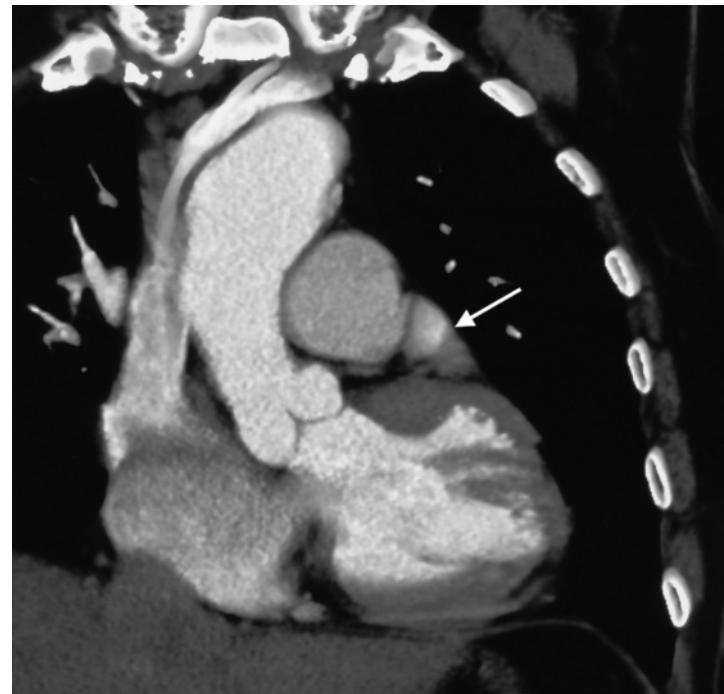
Visualization of the aortic root on CT. Paracoronal reconstruction of the left ventricular outflow tract with the aortic valve and aortic bulb. Both the heart as a whole and the left atrium are enlarged (atrial appendage; white arrow).
